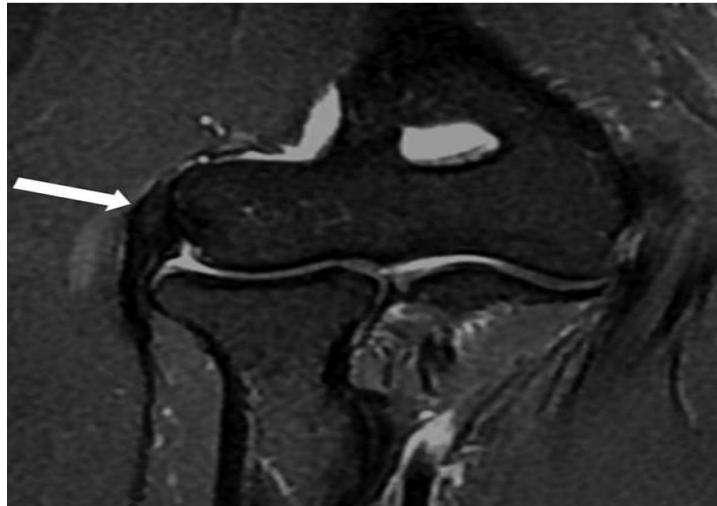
42-year-old man with right elbow pain 7 months (Tendinopathy score ¼ 1; PRTEE score ¼ 28). Coronal T2-weighted fat-suppressed MR image shows a mild focal increased tendon signal (white arrow). PRTEE¼ Patient-Rated Tennis Elbow Evaluation
